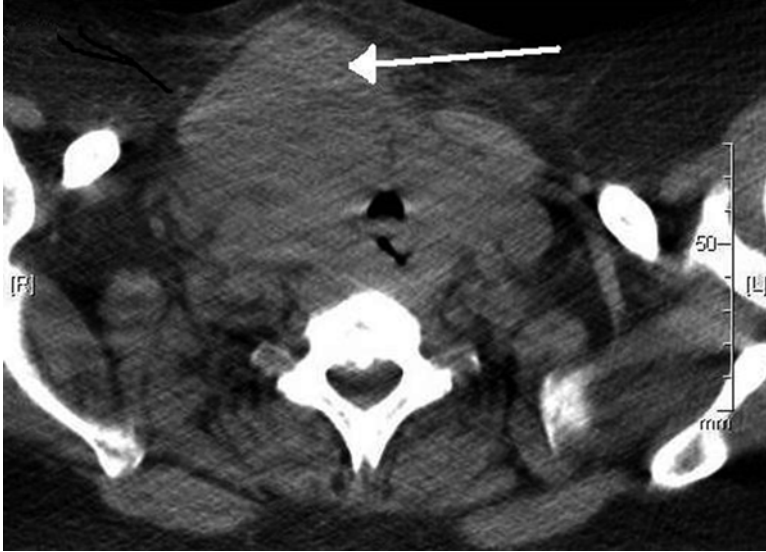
Pretreatment computed tomography scan of the soft tissues of the neck. An irregular shaped mass in the right thyroid lobe measuring 8.7 cm in largest dimension extending around the esophagus and narrowing the airway can be appreciated. Multiple enlarged lymph nodes can also be noted
